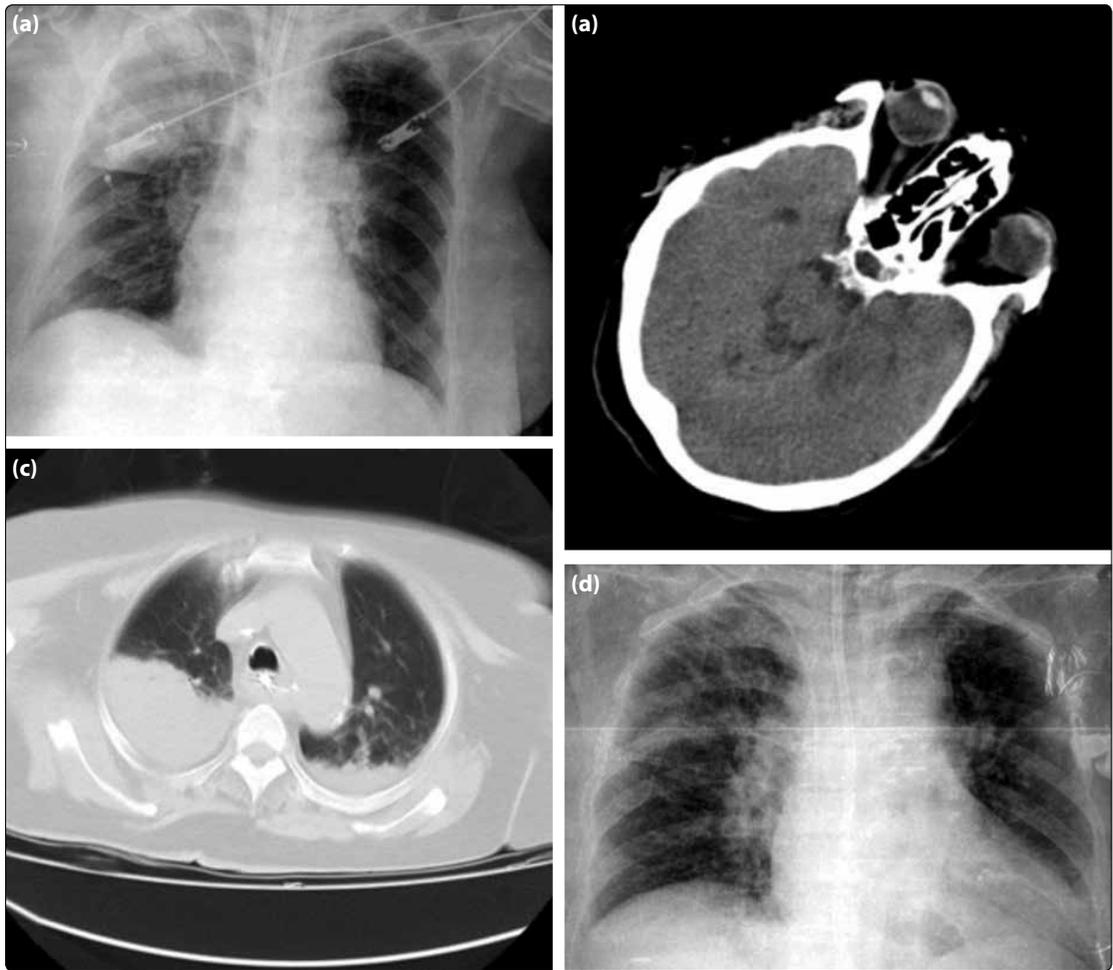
ICU (a) chest X-ray at admission, (b) cranial CT at admission, (c) thoracic CT at admission, (d) chest X-ray at discharge.
